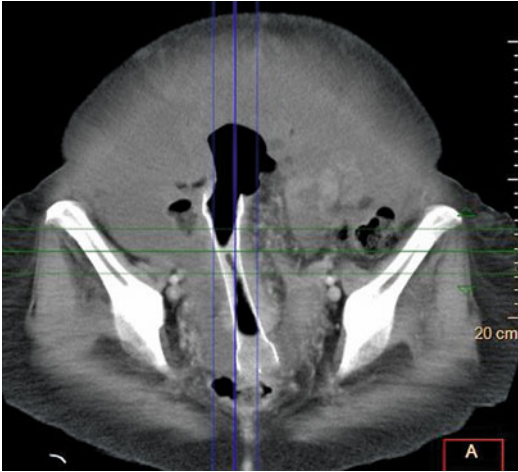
Colonic stent. Oblique axial CT reformat demonstrating stent position
